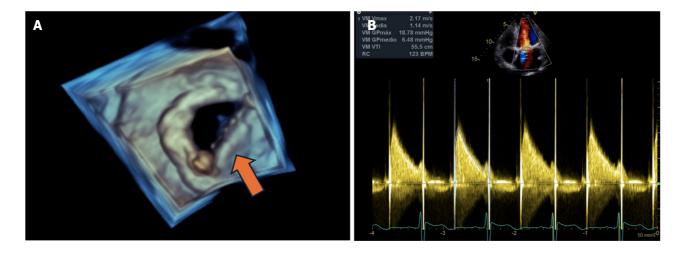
Post-thrombolysis corrected mitral valve prosthesis in transthoracic echocardiography. A: Mitral valve prosthesis viewed from the atrium with two open hemidiscs (arrows); B: Transvalvular mitral valve gradient after thrombolysis. Mean gradient of 1.8 mmHg.
